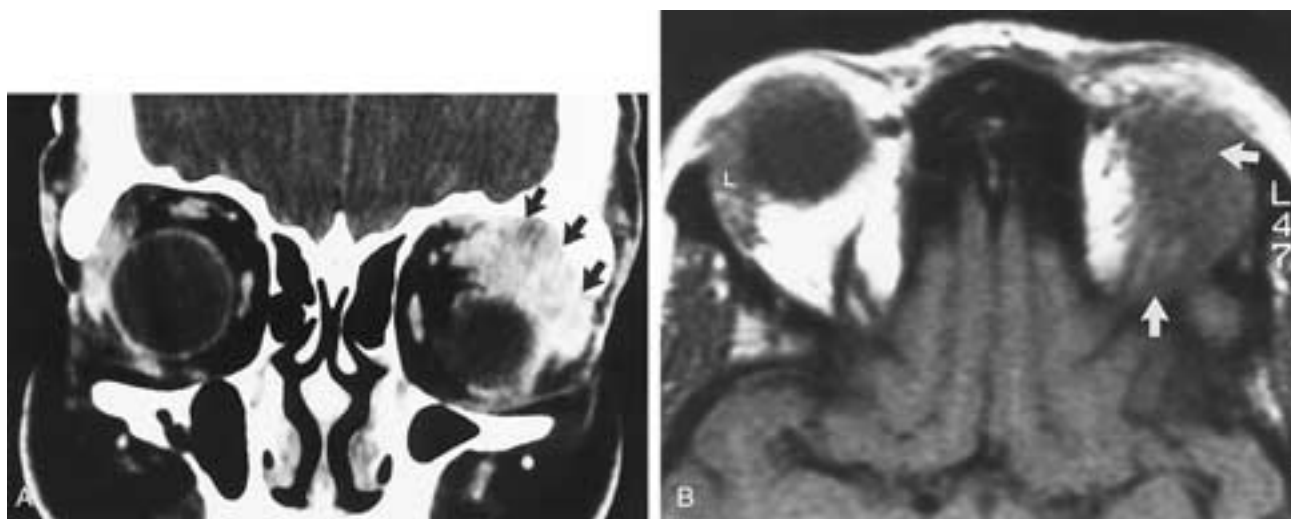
Orbital pseudotumor. A, Enhanced coronal CT scan. B, Axial T1-weighted axial MR scan showing an irregular mass involving the left lacrimal gland and adjacent orbital tissues (arrows).
